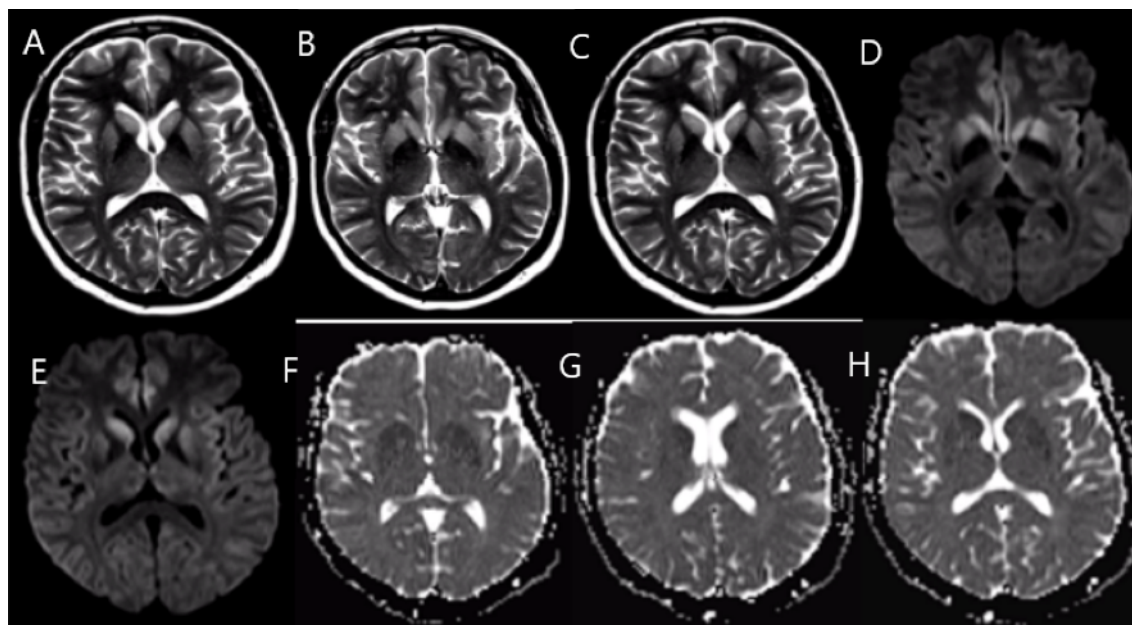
Brain magnetic resonance imaging scans demonstrating hypersignal in bilateral basal ganglia, insula, and anterior cingulate gyrus in T2 sequence (A, B, C) and hypersignal in the same regions in the diffusion sequence (D, E) with corresponding low signal in the ADC map (F, G, H), characterizing a true restriction to water molecules.
